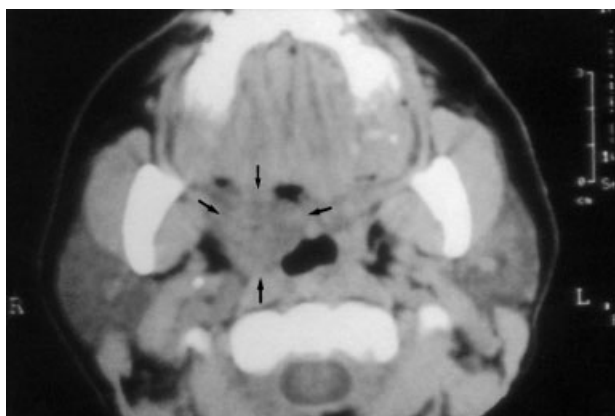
CT of the lesion demonstrating the unilocular homogenous well defined mass in the area of the right soft palate.
